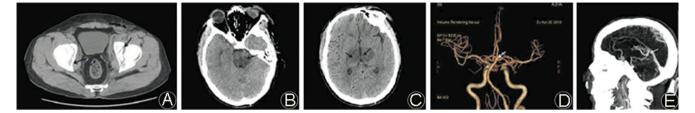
A: Axial CT scan of the hip showing bilateral acetabular fractures on admission. B, C: Axial CT scan of the head showing bilateral thalamus and brainstem infarction. D: Computed tomography arteriogram of the brain showing normal blood vessels. E: Computed tomography venography of the brain showing Galen vein thrombosis.
